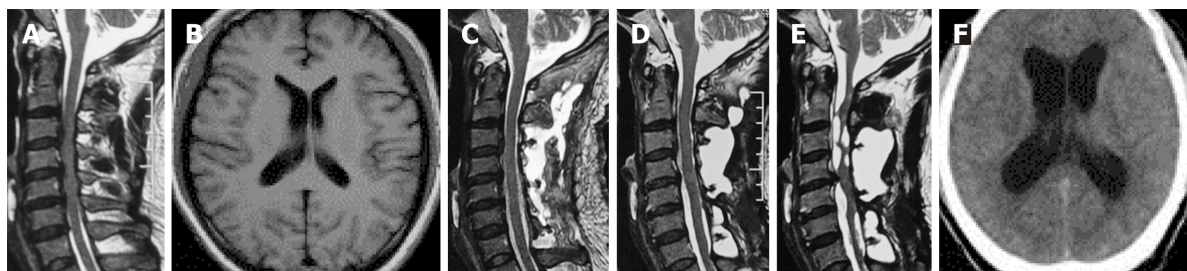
Previous imaging data at a local hospital. A: Sagittal T2-weighted cervical magnetic resonance (MR) image before laminoplasty surgery revealing cervical spinal stenosis; B: Axial T2-weighted MR image before laminoplasty surgery showing a normal ventricle; C and D: Sagittal T2-weighted MR image showing obvious cerebrospinal fluid leakage without subdural fluid collection at 1 and 8 mo after cervical laminoplasty; E: Cervical MR image at 9 mo after laminoplasty surgery demonstrating a cystic lesion around the cervical spinal cord and medulla oblongata; F: Head computed tomography scan at 9 mo after cervical laminoplasty revealed hydrocephalus with marked enlargement of the ventricular system without any occupying lesion.
